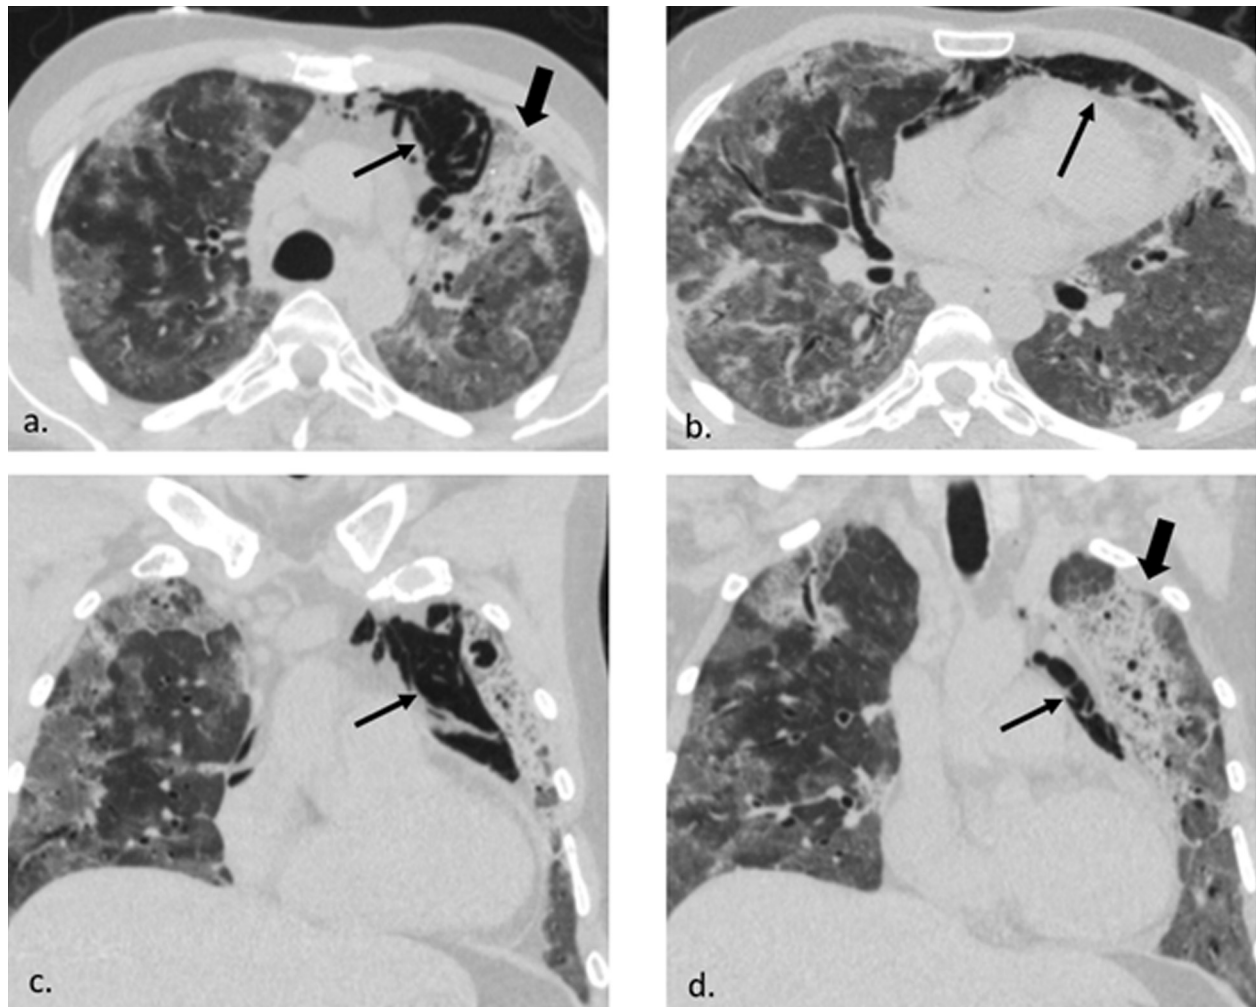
Non Contrast CT of the chest (lung window): a, b - Axial image showing ground glass opacity and interlobular septal thickening. Consolidation with passive atelectasis of anterior segment of left upper lobe (Box arrow), pneumomediastinum (line arrow). c, d- Coronal images: Consolidation in left upper lobe (box arrow) and pneumomediastinum (line arrow).
